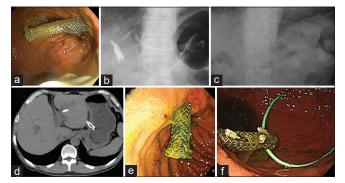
A case of life-threatening stent migration into the abdominal cavity after endoscopic ultrasonography-guided hepaticogastrostomy (EUS-HGS) (a) Endoscopic view of the partially covered self-expandable metallic stent (PCSEMS) after EU-HGS. The length of the protruding portion in the stomach was about 60 mm (b) Final X-ray image of EUS-HGS (c) Abdominal X-ray image the day after EUS-HGS, indicating that the stent had not migrated (d) Routine plain CT image the day after EUS-HGS. The length of the stomach was <20 mm and the stent was recognized as a life-threatening migration (e) Endoscopic view of the HGS stent in the stomach. The length of the protruding portion was almost 20 mm (f) Anchoring procedure with plastic stent and metallic clips. Plastic stent penetrates the stent body and the "ClipFlap" technique was performed
